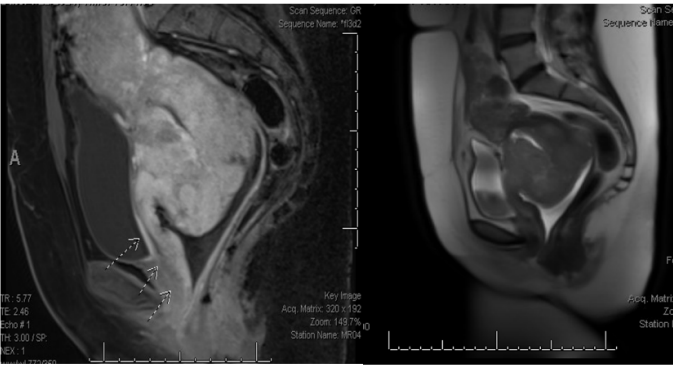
MRI pelvis with and without intravenous contrast at diagnosis.
